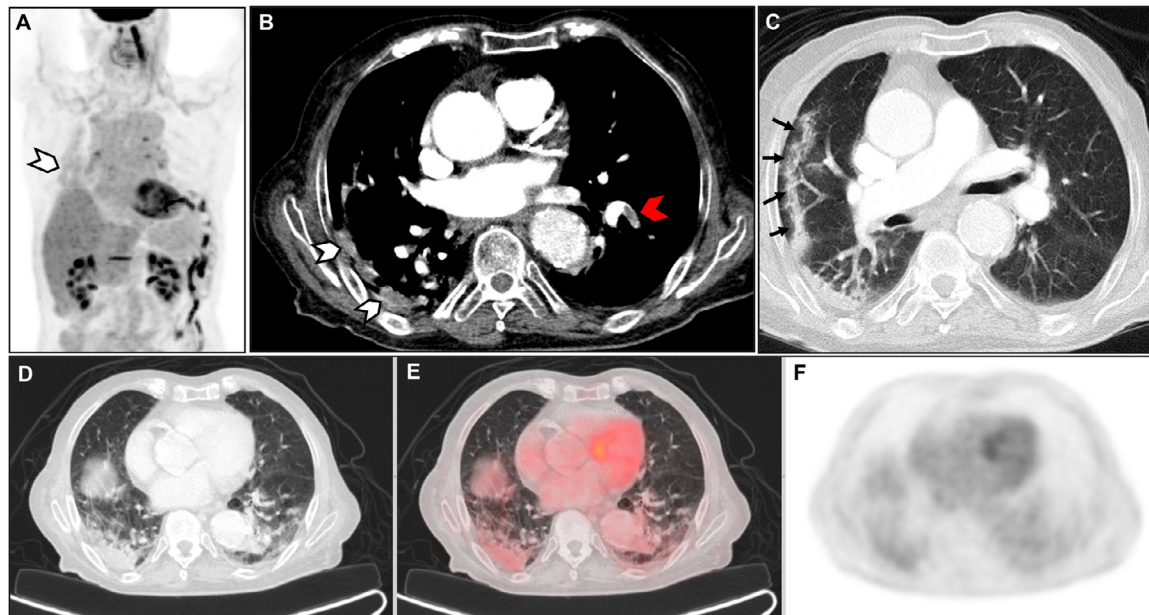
Tomographic and molecular chest findings PET maximum intensity projection (MIP) image (A) revealed increased accumulation of FDG, predominantly in the right lung (white arrowhead). On axial images (lung and mediastinal windows, B and C), a thrombus was depicted within a left lower lobe segmental branch (red arrowhead) in addition to basal right lung infiltrates (white arrowheads). Axial CT (lung window, D), PET-CT and PET images show bilateral ground-glass opacities and lineal right subpleural bands (black arrows) with FDG uptake (SUVmax: 3.2).
